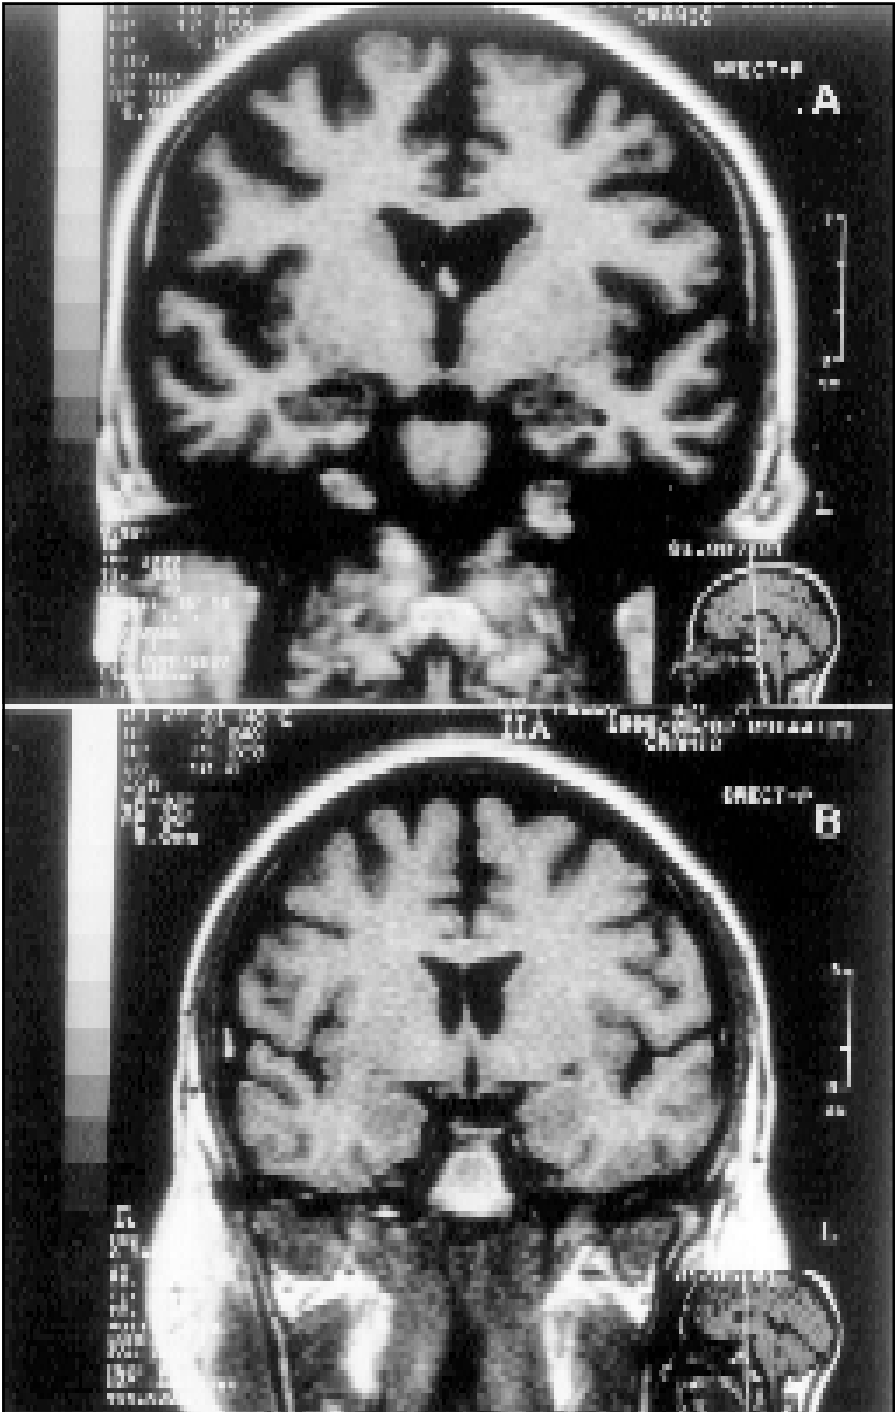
A - Patient's MRI, coronal T1-weighted section, shows marked bilateral sulci widening involving both frontal lobes; B - Age and sex-matched MRI control, T1-weighted coronal section.
